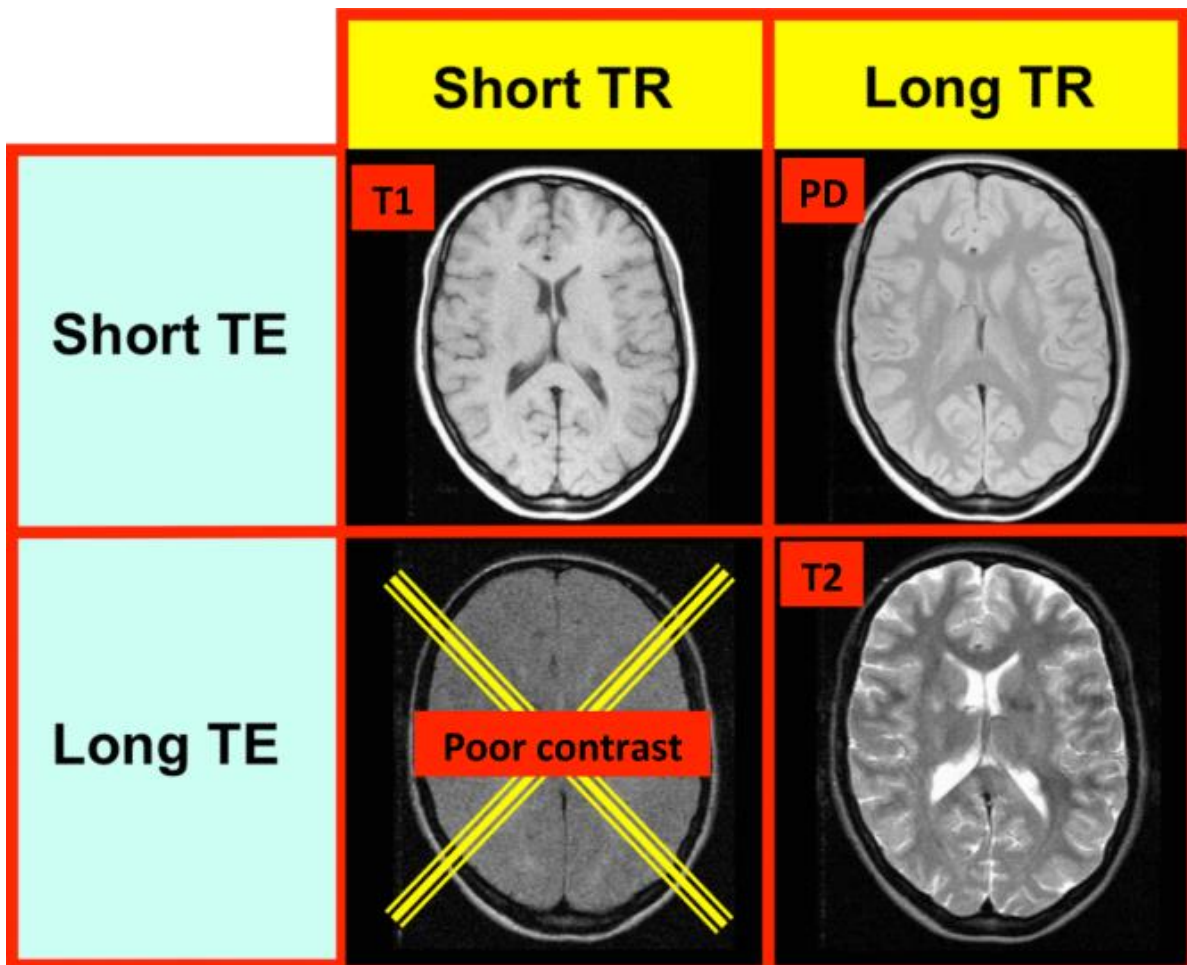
Generation of MRI brain image contrasts
